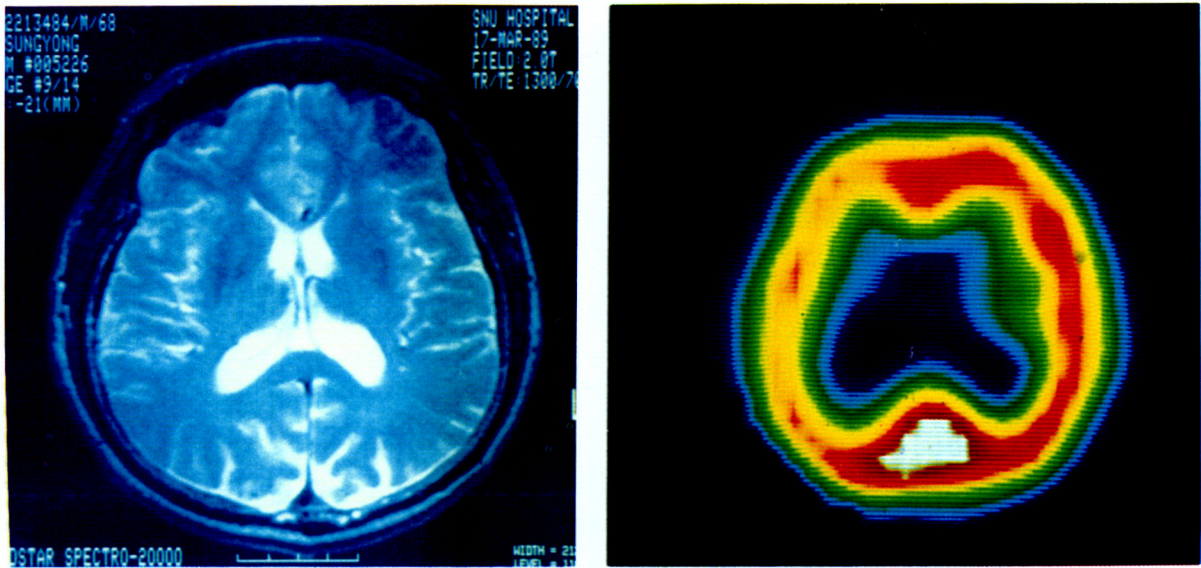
Patient with TIA. Although his MR (left) showed no abnormality, a SPECT image (right) revealed decreased perfusion in the right frontoparietal cortex.
